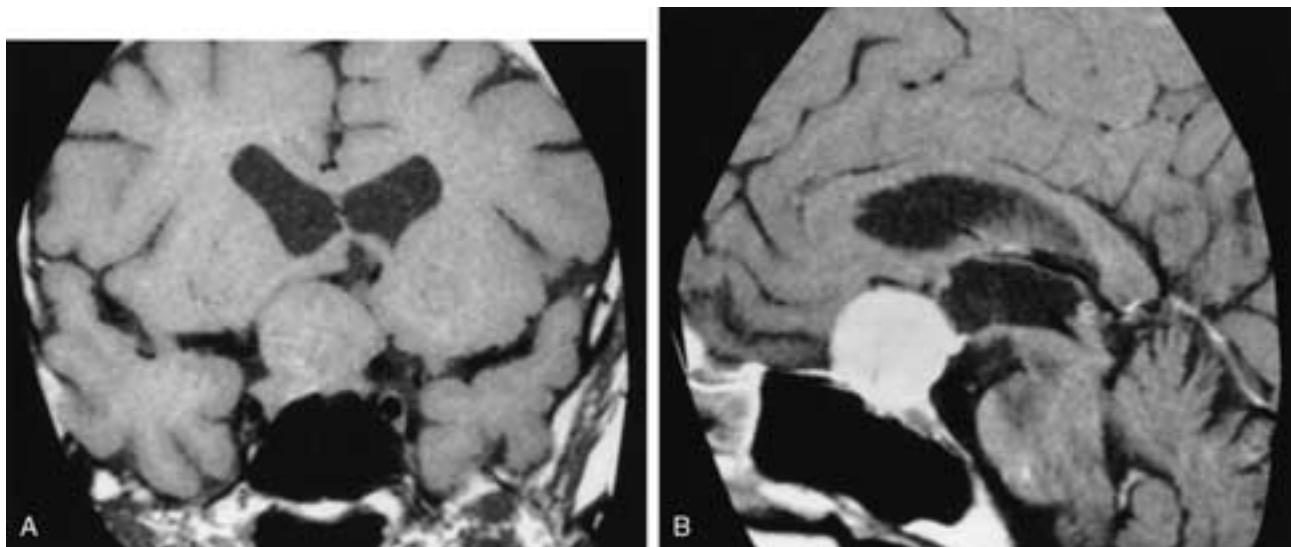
Pituitary adenoma in a 40-year-old male with bitemporal hemianopsia. A, Coronal T1-weighted image shows a large intra- and suprasellar mass stretching the chiasm from below. B, Sagittal T1-weighted image shows the adenoma enhancing. Note that the tumor did not expand into the aerated sphenoid sinus but upward, indicating an open diaphragma sellae.
